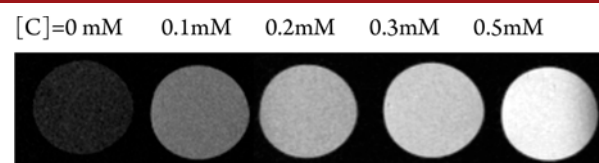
T_1 -weighted MRI images of 4 hemicryptophane–Gd(III) solutions with the following concentrations (from left to right): 0 mM, 0.1 mM, 0.2 mM, 0.3 mM, and 0.5 mM. Solvent: 70/30 DMSO- d_6 /H₂O.
